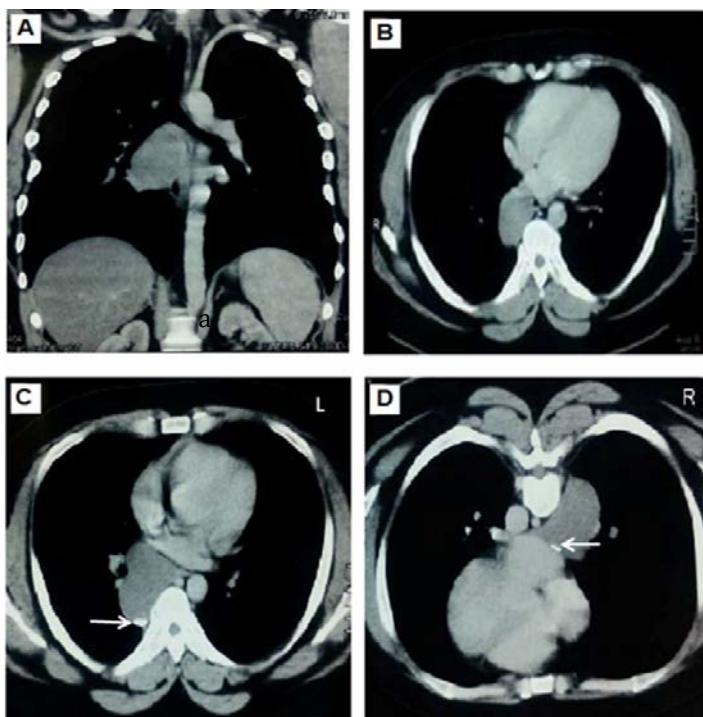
Contrast enhanced chest CT with non-enhancing sub-carinal bronchogenic cyst in the posterior mediastinum: axial view (A), and coronal view (B), with posteriorly located calcific focus (arrow) on supine position (C), which changes its location anteriorly (arrow) on prone position (D).
